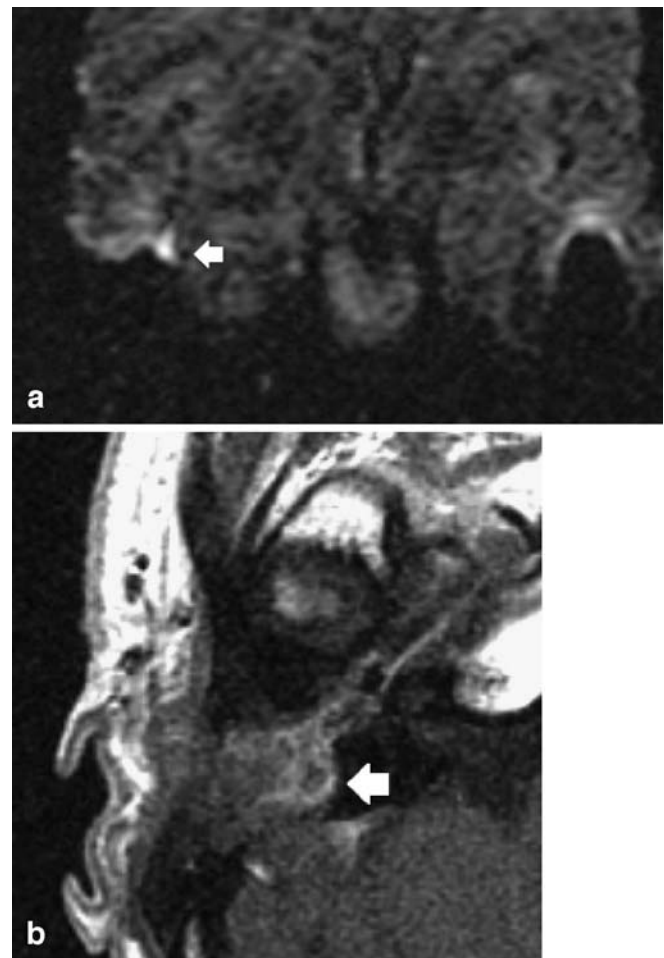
a A 51-year-old male planned for second look surgery. MR imaging prior to second-look surgery shows a nodular hyperintense lesion under the tegmen on echo-planar DWI imaging (*arrow*). b Same patient as in a. Axial contrast-enhanced T1-weighted MR image shows a peripheral enhancing nodular lesion, suggestive of cholesteatoma. Surgery revealed the presence of a residual cholesteatoma with a diameter of 6 mm
